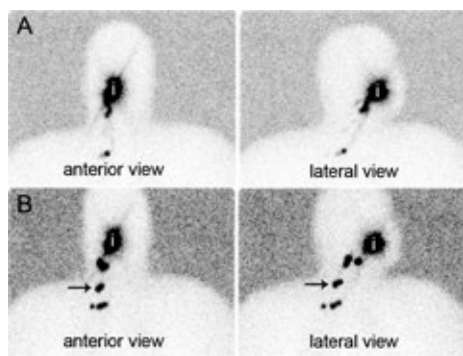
Early (A) and late (B) static lymphoscintigraphic imaging results of a patient with a cT2N0 lateral tongue carcinoma on the right side. During early image registration, hot foci were clearly visualized in level IIA and IV on the right side, with additional hot foci considered to be SNs detected during late imaging, of which two were located at a different level of the neck (level III, arrow). A positive SN was found in a lymph node harvested from level IV on the right side. Subsequent modified radical neck dissection showed no additional metastatically involved lymph nodes.
